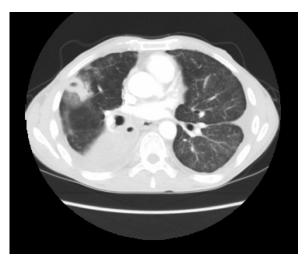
Thoracic computed tomography scan performed before bevacizumab showing bilateral pleural effusion, condensation with a small cavity in the right-lower lobe, peripheral opacity in the middle lobe with round glass opacities.
